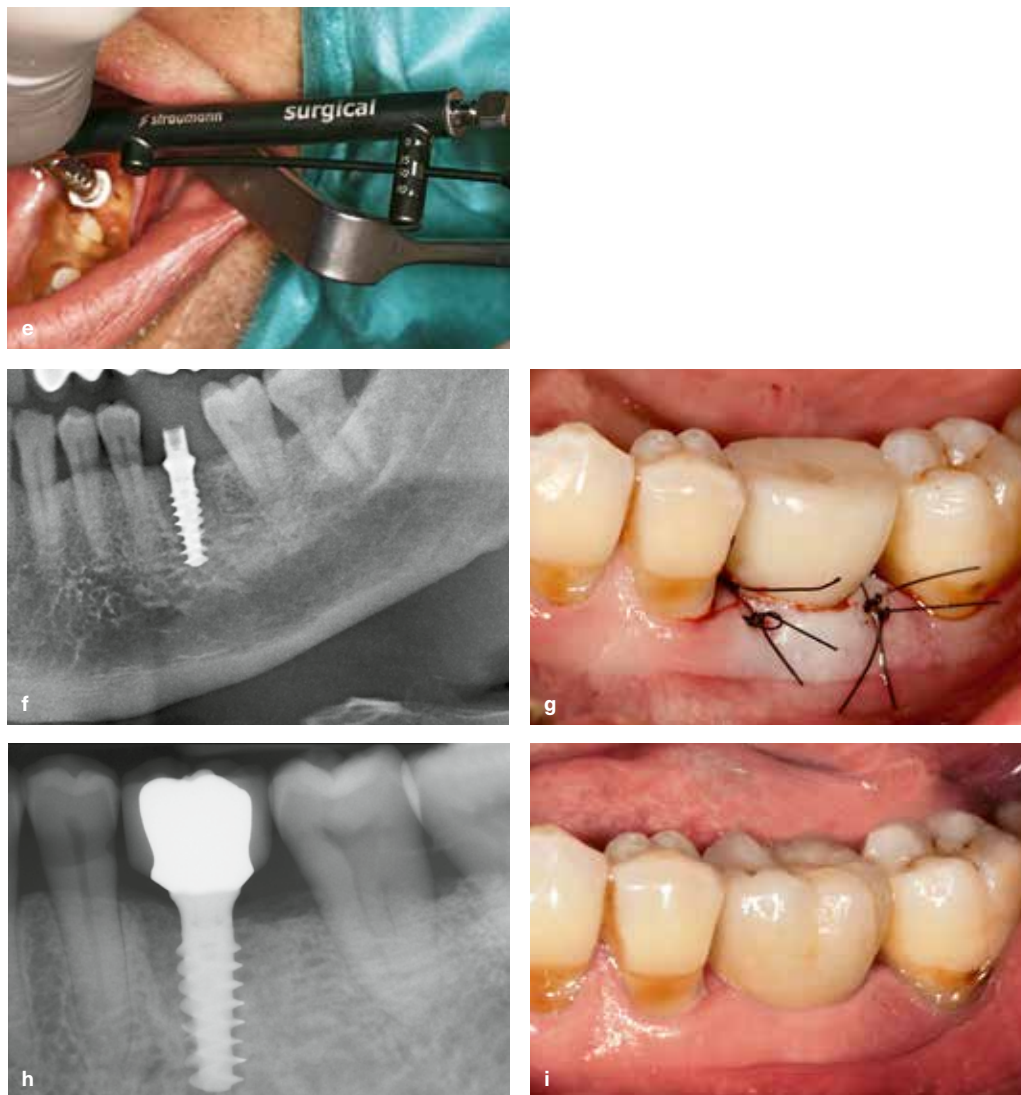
(cont) (e) Implant placed with 50 Ncm of insertion torque. (f) Immediate postoperative radiograph. (g) Immediate provisional secured. (h) Complete seating of the components with stable marginal bone levels. (i) Stable soft tissue levels with the definitive restoration in place.
